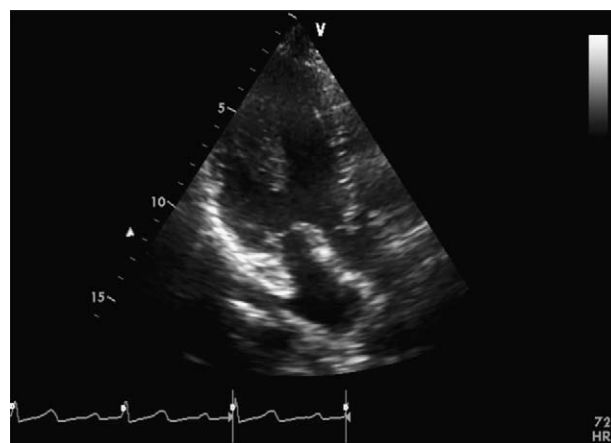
Transthoracic apical 3-chamber view showing similar marked thickening of the basal posterior and anterior left atrial wall.
